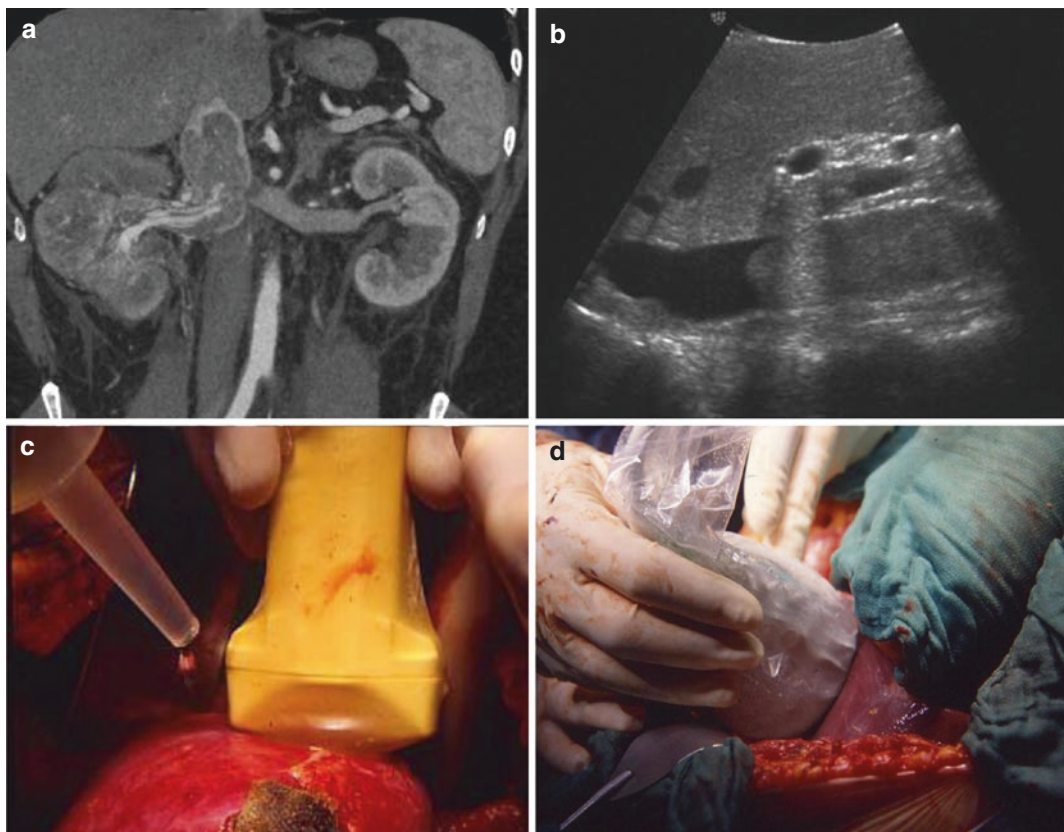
(a–d) A 43-year-old male patient with massive lesion of the right kidney. Coronal CT (a) shows the massive bone lesion of the right kidney with the presence of tumour thrombus in the vena cava. Intraoperative ultrasound (b) is performed with B-mode study that allowed us to confirm the cranial extension of the tumour thrombus in the vena cava. Some surgery moments of intraoperative
